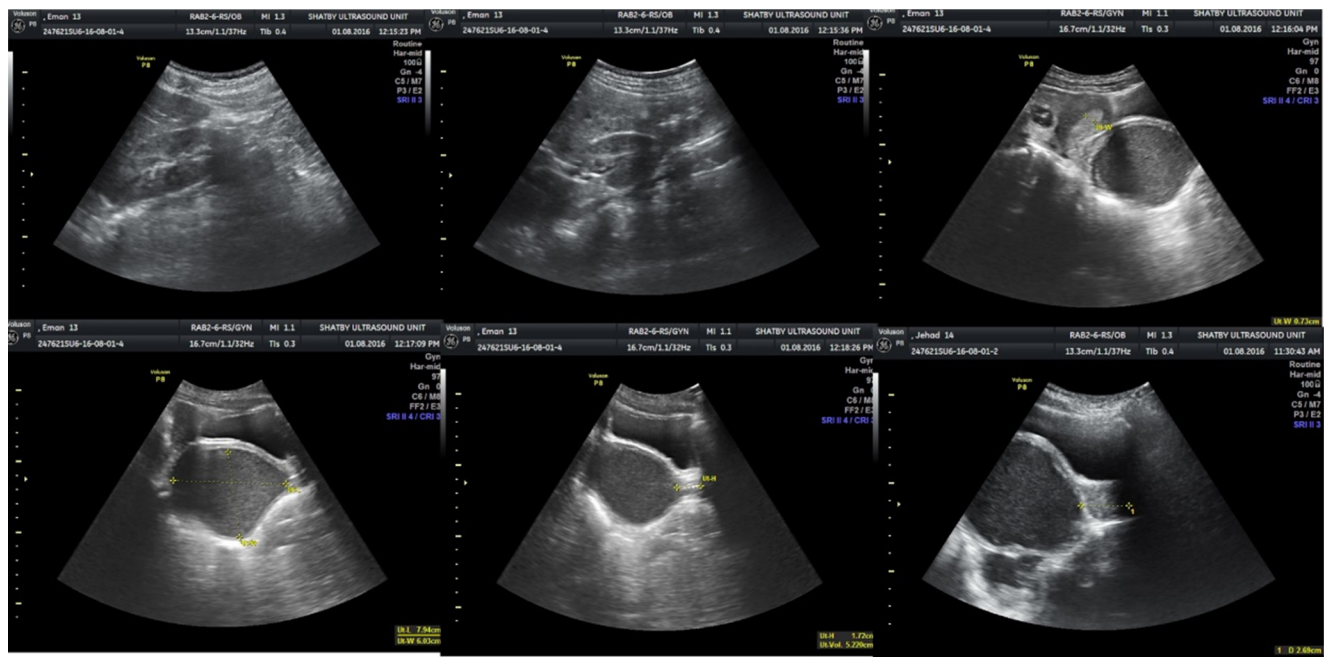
Ultrasound showing hematocolpos with septum about 1 cm in thickness and 5 cm from hymen with both kidneys seen
